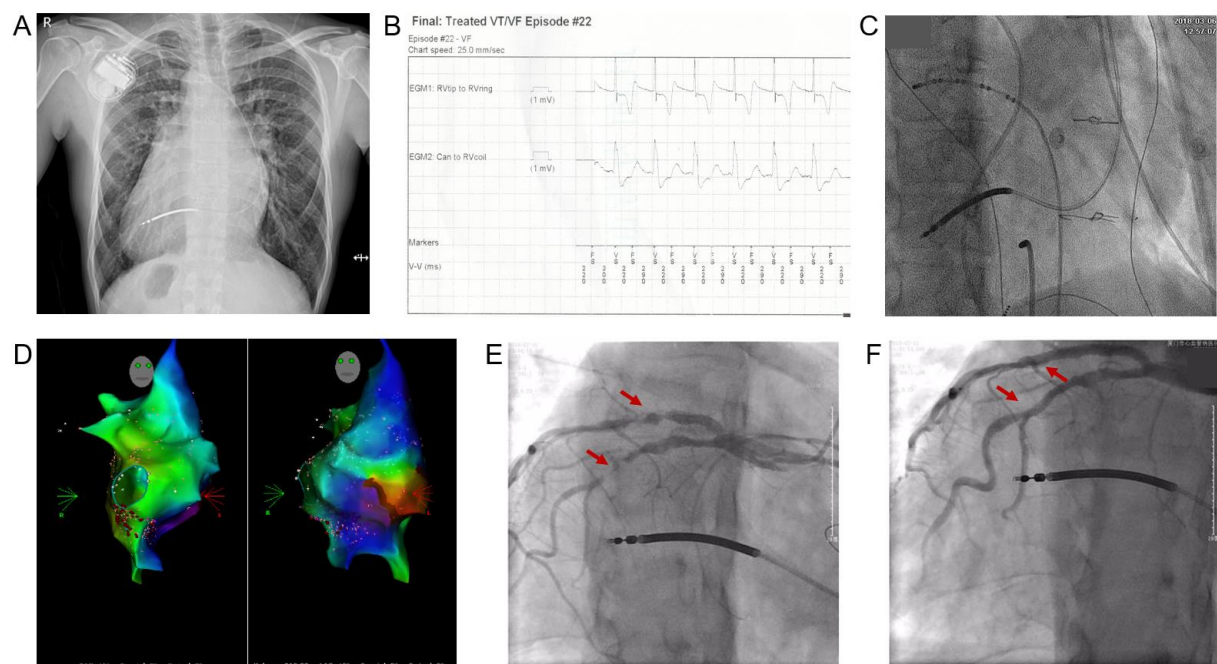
A: X-ray post ICD implantation showing right-deviated cardiac silhouette. B: Record extracted from the ICD mistaking AF for VF. C: Fluoroscopy during electrophysiology study. D: Mapping during radiofrequency ablation. E and F: Results from the coronary angiography, before (E) and after (F) stent implantation.
